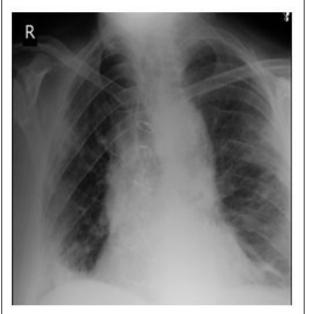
Chest X-Ray view. Consolidations and patch lesions
